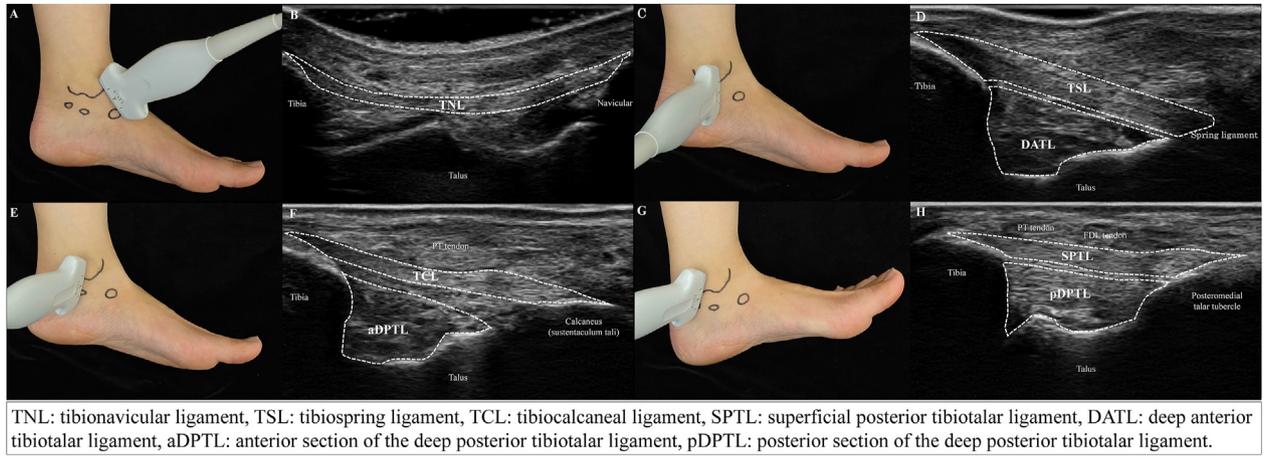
Probe positions and ultrasound findings. (A,B) Tibionavicular ligament. (C,D) Tibiospring ligament and deep anterior tibiotalar ligament. (E,F) Tibiocalcaneal ligament and anterior section of deep posterior tibiotalar ligament. (G,H) Superficial posterior tibiotalar ligament and posterior section of the deep posterior tibiotalar ligament.
